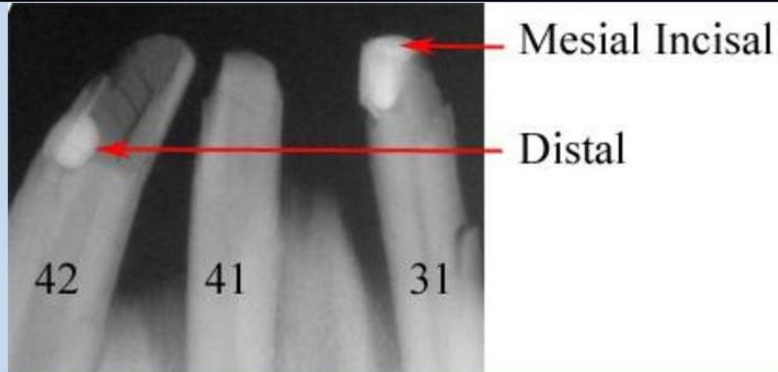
Postmortem radiographs of the same area as Fig. 5 with the 31, 41 and 42 teeth correctly orientated.
